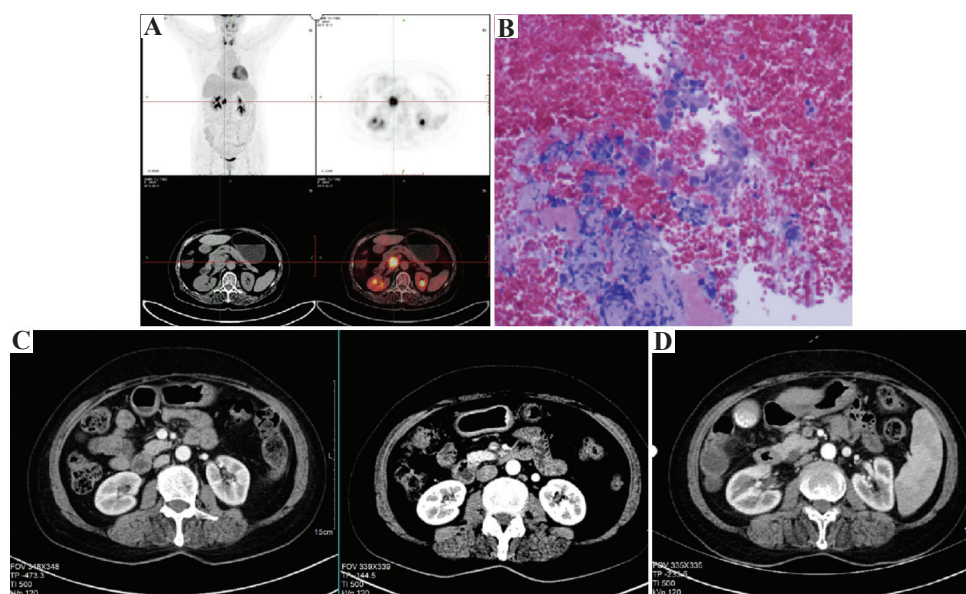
Comparison of imaging data of Case 2 after conversion therapy. (A) Positron emission tomography computed tomography (CT) indicated high fluorodeoxyglucose metabolism and no distant metastasis. (B) The finding of endoscopic ultrasound-guided fine-needle aspiration biopsy suggested the development of carcinoma in the pancreas. (C) Enhanced CT indicated partial response of the lesion (13×11 mm vs. 22×26 mm). (D) Enhanced CT indicated complete response of the lesion to the treatment.
